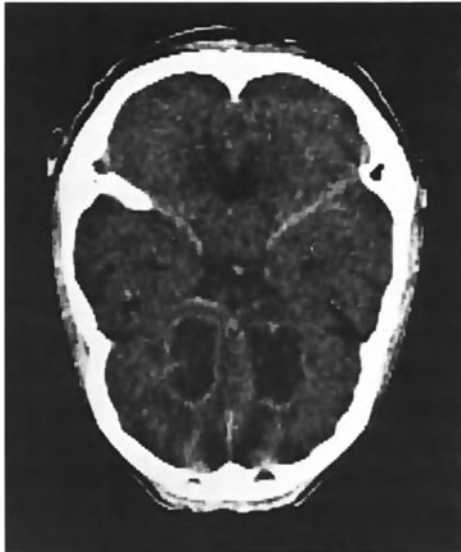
Subcaudate tractotomy of Knight on axial CT-scan after extension of the lesion
